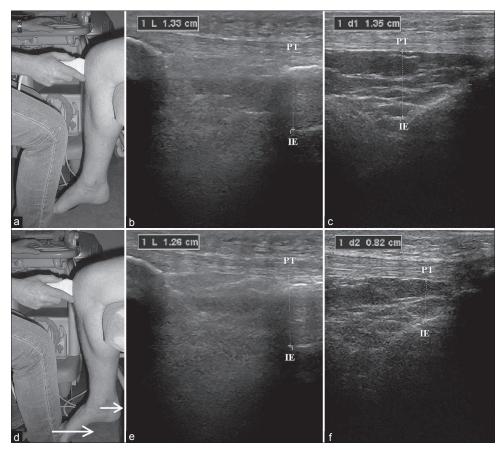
Ultrasonographic evaluation of anterior knee translation during the shift of the intercondylar eminence against the patellar tendon. Arrows indicate the direction of the force applied in moving the shin from a start (a) to an end (d) position. Corresponding ultrasound image in a patient with an intact anterior cruciate ligament (ACL) (b and c) and an insufficient ACL (e and f)
